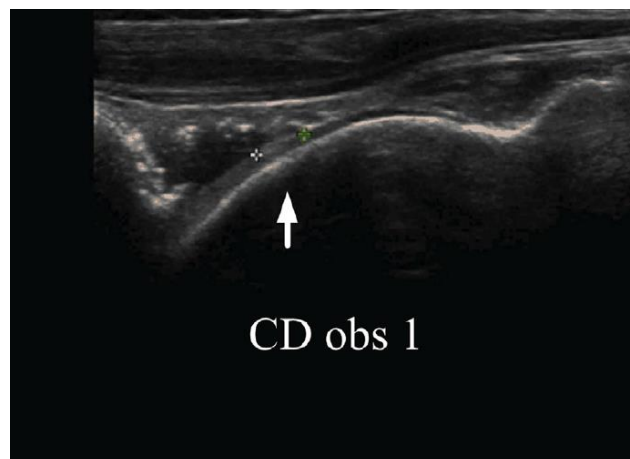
Ultrasound image of the ankle joint. The arrow indicates a defect in the cartilage. The visible cartilage surface is limited by the tibia which surround more than 60% of the talar surface. Source: Tuijthof et al. 2014 (11).
